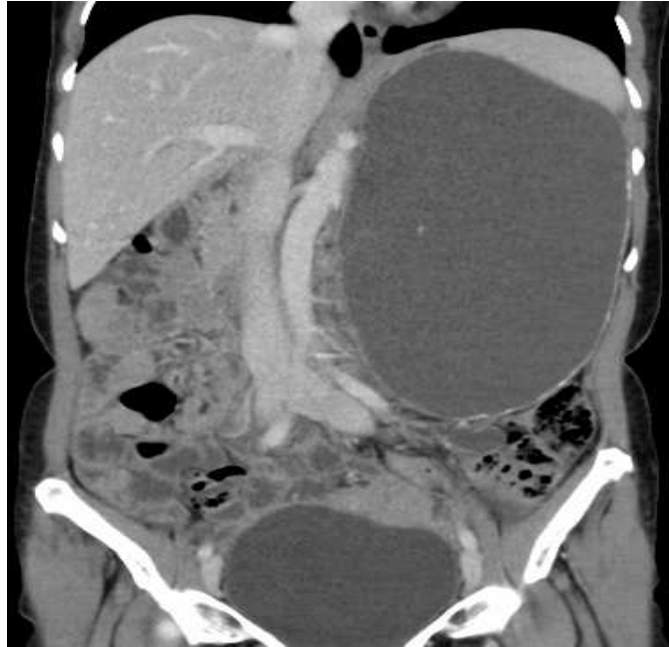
(a) CT scan showing giant left adrenal cystic lesion (Coronal section).
